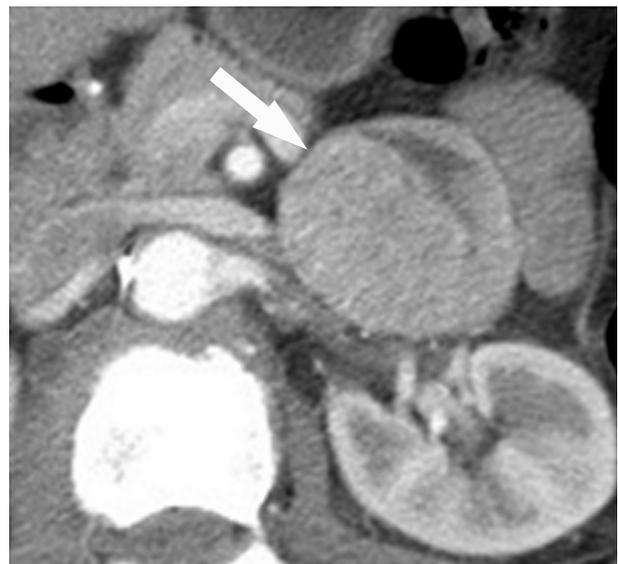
Axial contrast-enhanced portal venous phase CT scan in a 76 year old woman undergoing preoperative staging of a cecal mass (Case 1 in Table-1). A homogeneously enhancing right adrenal mass (arrow) is seen, and showed less than 50% washout on delayed images (not shown). The patient proceeded to right hemicolectomy and adrenalectomy, because the working diagnosis before surgery was of possible adrenal metastasis. Surgery was complicated by hemodynamic instability and a postoperative non-Q wave myocardial infarction. Final pathology revealed a cecal tubulovillous adenoma and an adrenal pheochromocytoma.
